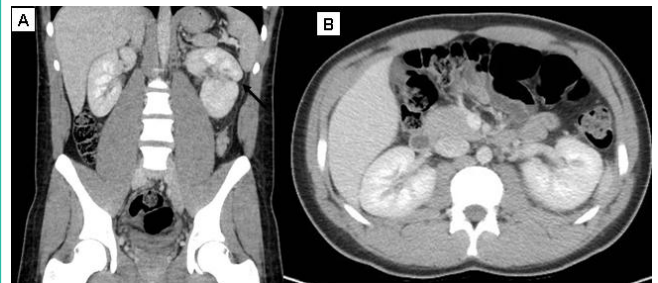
Case 2. Control contrast-enhanced helical CT scan performed 45 days after the renal injury. It has decreased renal laceration (arrow) and perirenal hematoma is gone.
